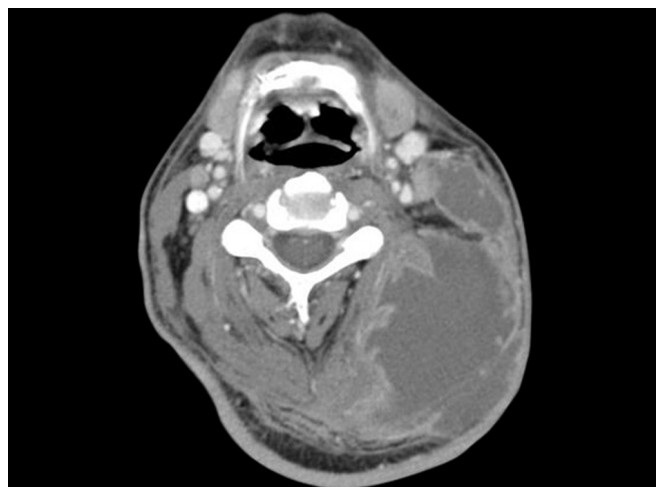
Neck abscess CT. The CT scan with contrast for the same patient reveals the extensive collection within the neck spaces that has spread inferiorly from the mastoid.
